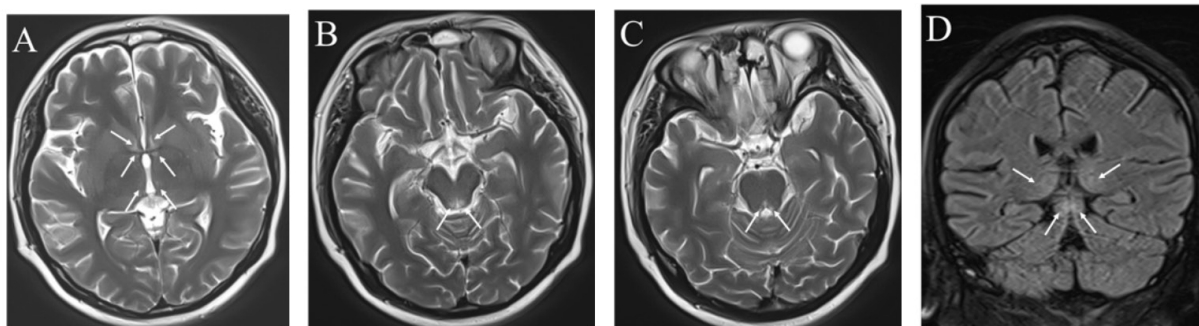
Brain MRI showed bilateral high-signal intensity lesions surrounding the cerebral aqueduct and thalamic regions, a typical finding of WE
